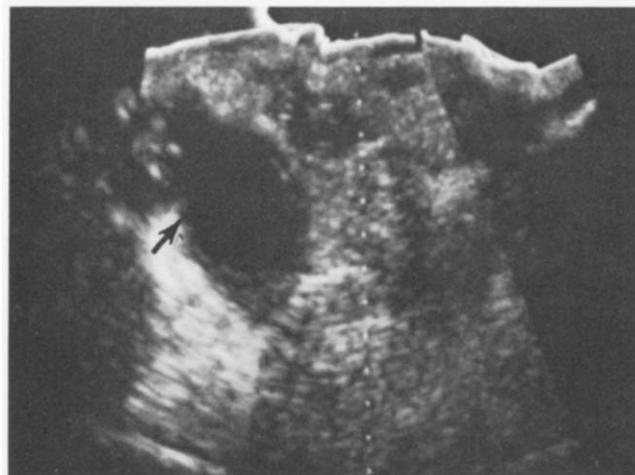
Abdominal ultrasound demonstrates an area of fluid accumulation (arrow) in the abdomen at the site of prior abscess formation.
